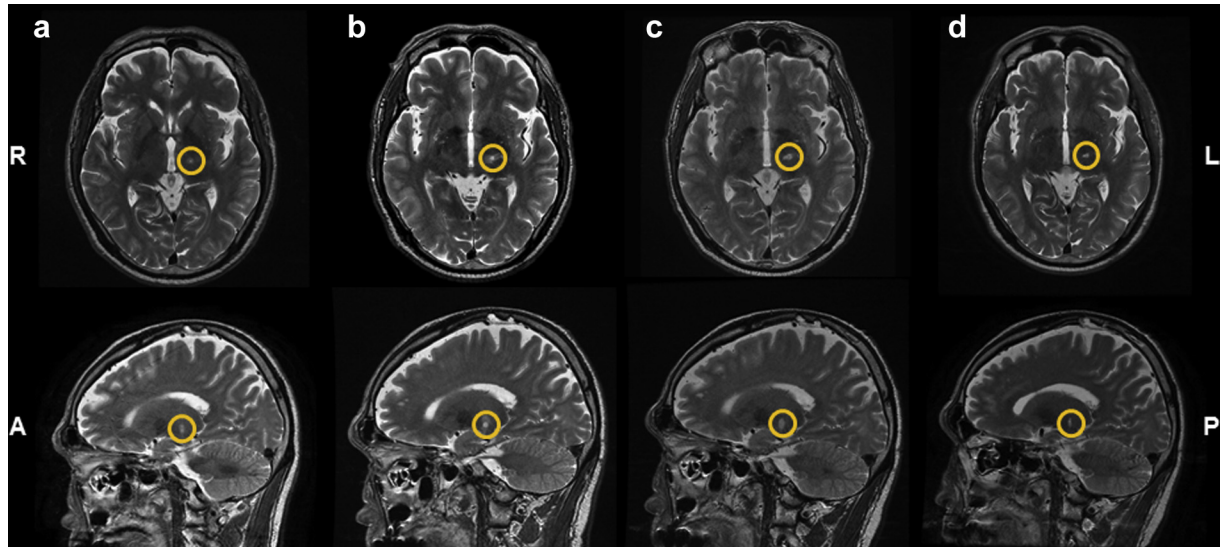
Images from a 3-T magnetic resonance imaging scanner (T2-weighted sequences) in a patient with essential tremor after sonication treatment. The patient was treated with transcranial magnetic resonance imaging-guided high-intensity focused ultrasound to create a lesion in the ventralis intermedius nucleus of the left thalamus (highlighted with *yellow circles*). (a) Immediately after magnetic resonance imaging-guided high-intensity focused ultrasound thalamotomy, (b) 1 wk post-operation, (c) 1 mo post-operation, (d) 3 mo post-operation. In the upper row are horizontal images (L = left; R = right), and in the lower row are the corresponding sagittal images (A = anterior, P = posterior).
